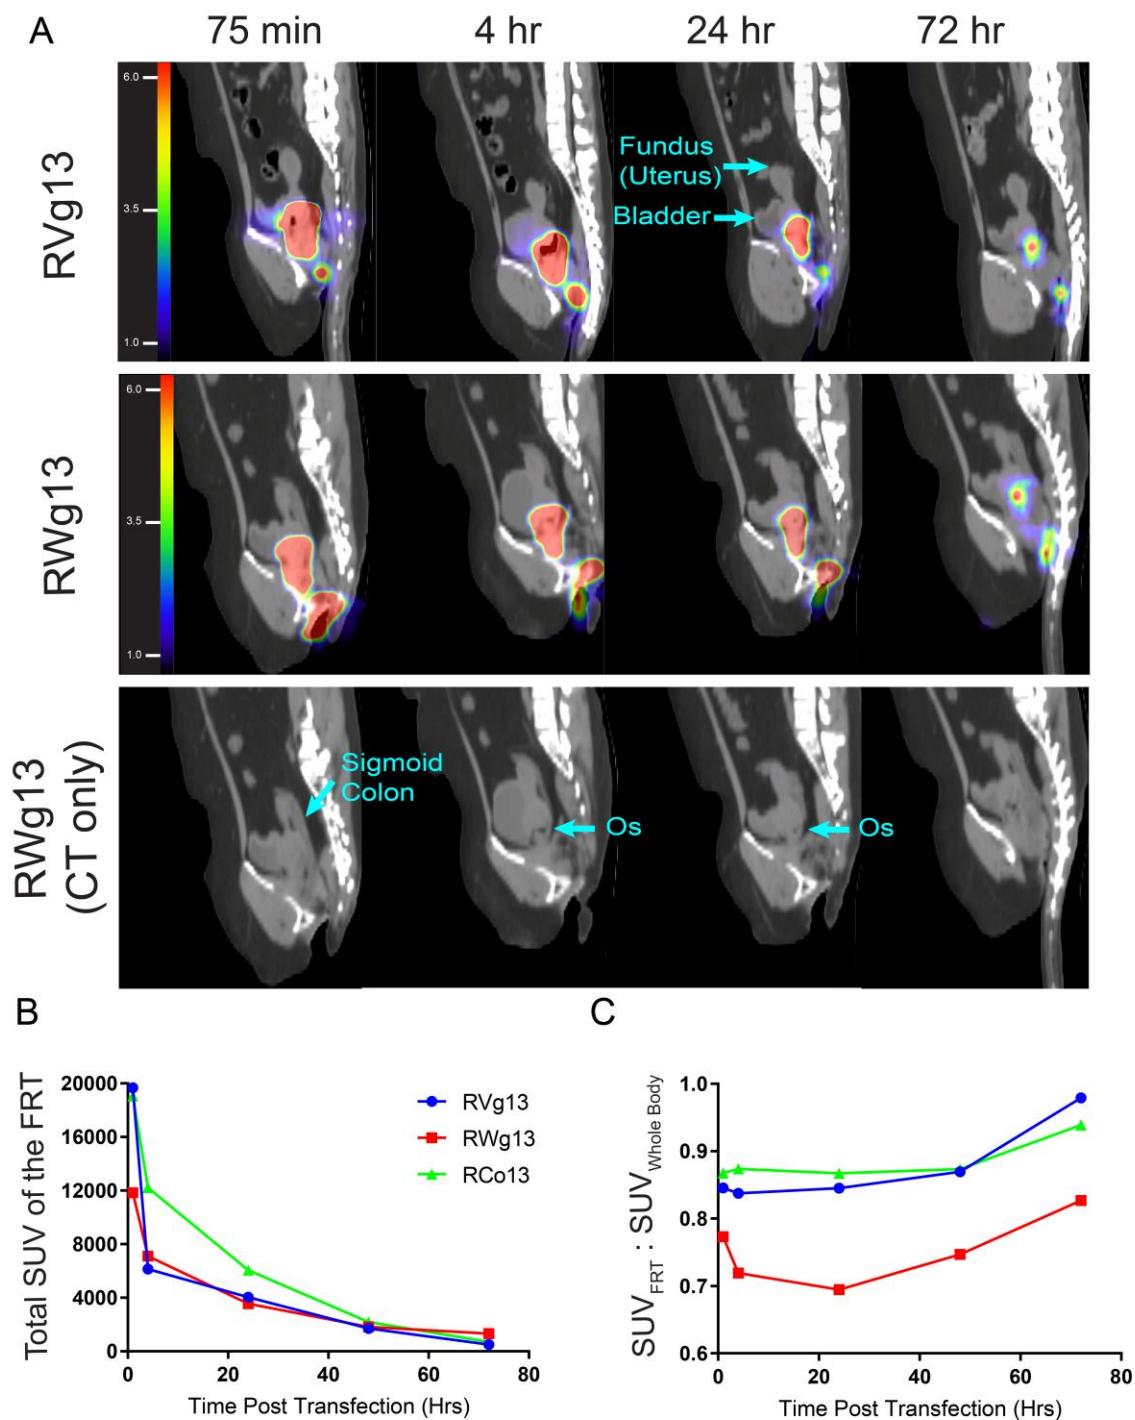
Radiolabeled mRNA is retained in the FRT following transfection. Two 125ug doses of ^{64}Cu labeled aPGT121 mRNA were delivered via aerosol to first the cervix, then ~ 3-4cm caudally in the vagina. PET/CT imaging over 3 days was used to monitor mRNA biodistribution. (A) representative PET/CT images from 75 minutes to 72 hours. (B) The total SUV in the FRT over time. (C) The ratio of the total SUV in the FRT to the total SUV contained within the entire body.
